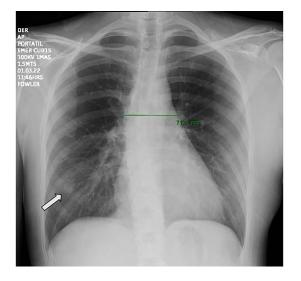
Anteroposterior chest radiography. Apparently widened mediastinum is seen, measuring 7 cm. In the right breast, there is a radiopaque and round mass (arrow). There are no pulmonary findings.
